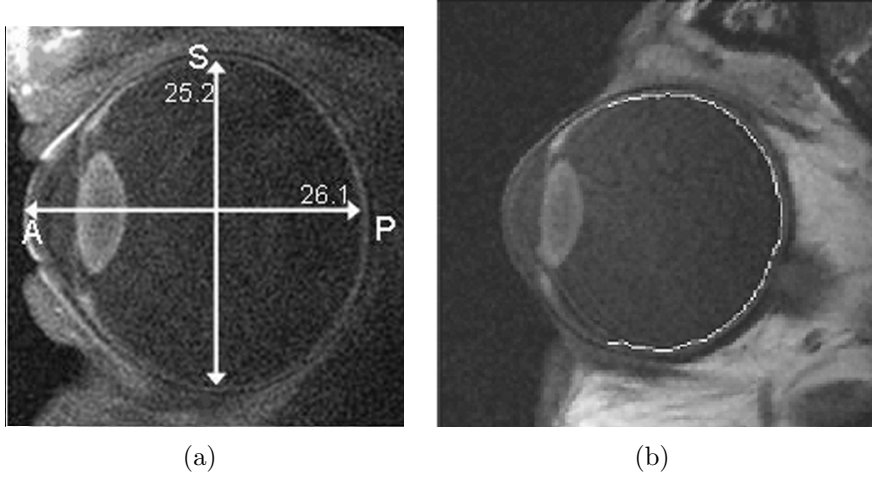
Biometric measurements from MRI images: (a) axial length, (b) retinal shape. Images taken from [Atchison *et al.*, 2004] and [Atchison *et al.*, 2005], respectively.
